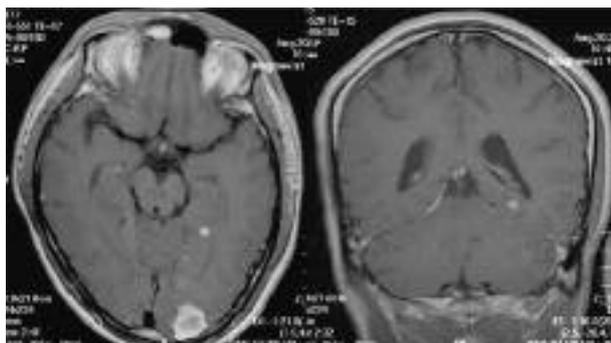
Axial and coronal T1-weighted magnetic resonance (MR) imaging with contrast medium showed two well-enhanced masses in the left occipital and deep left temporal lobes.
